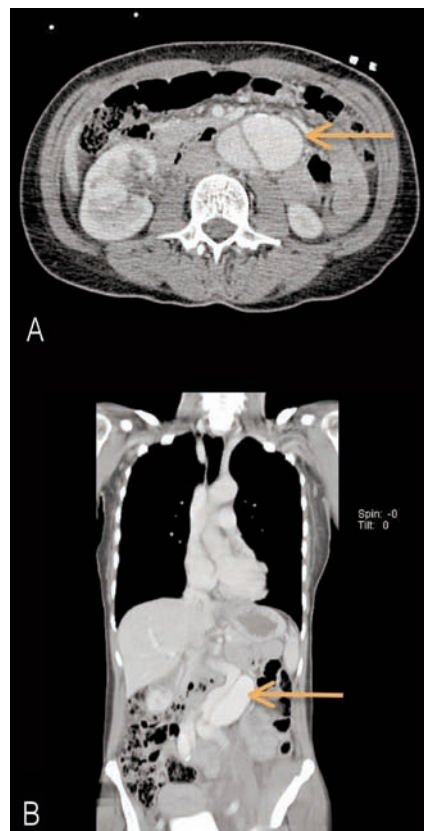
Computed tomography scan of the abdomen shows the dissection of the infrarenal abdominal aorta. A) Axillary and B) coronal view.
